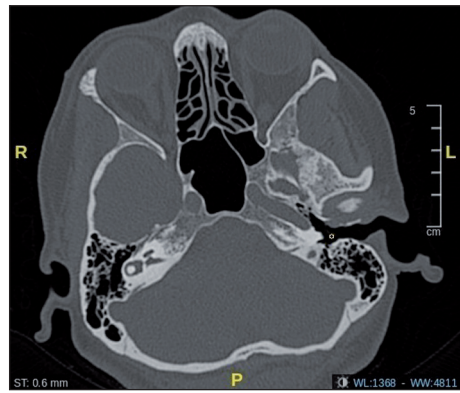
Axial section of computed tomography indicated temporomandibular joint dehiscence on left side (asterix).
